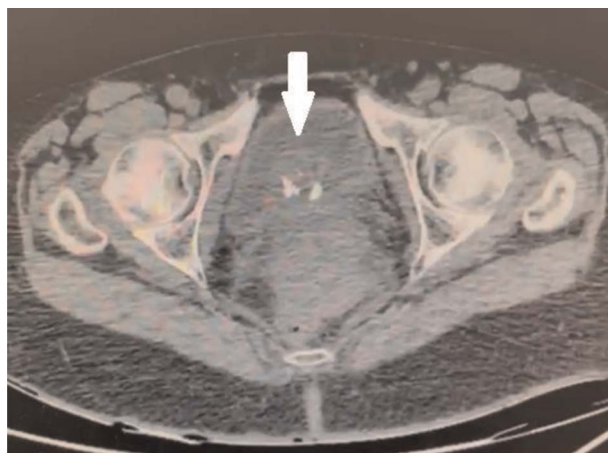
Axial CT image of pelvis with arrow indicating urethral tumor. CT, computed tomography.
